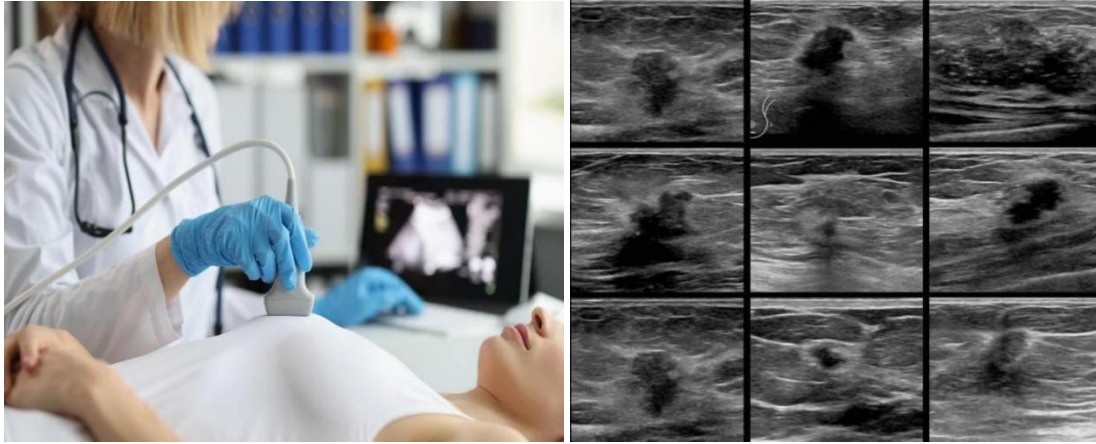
Breast ultrasound imaging (<https://radiologyassistant.nl/breast/ultrasound/ultrasound-of-the-breast>).
